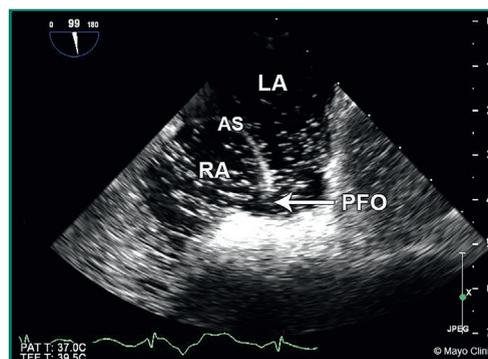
Bubble study demonstrating right-to-left shunt on an transesophageal echocardiogram. Microbubbles have crossed from RA to LA, indicating right-to-left shunt across a PFO. AS, atrial septum; LA, left atrium; PFO, patent foramen ovale; RA, right atrium.
